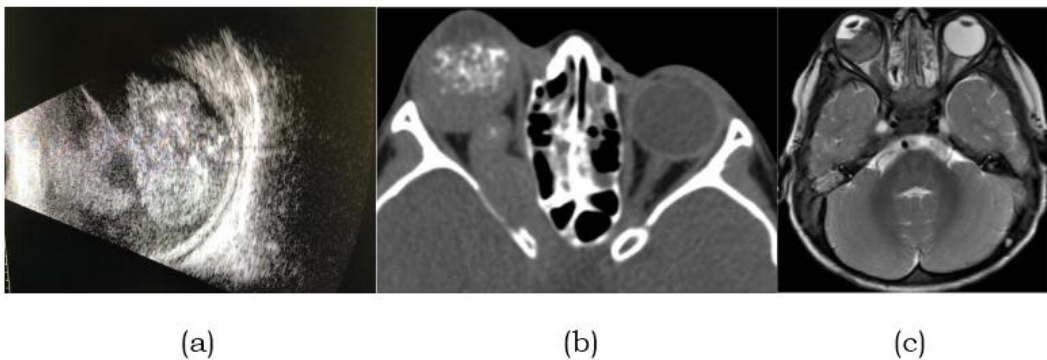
Retinoblastoma imaging modalities (a) Ultrasound (b) CT (c) MRI (Clinical Diagnostic procedures)
